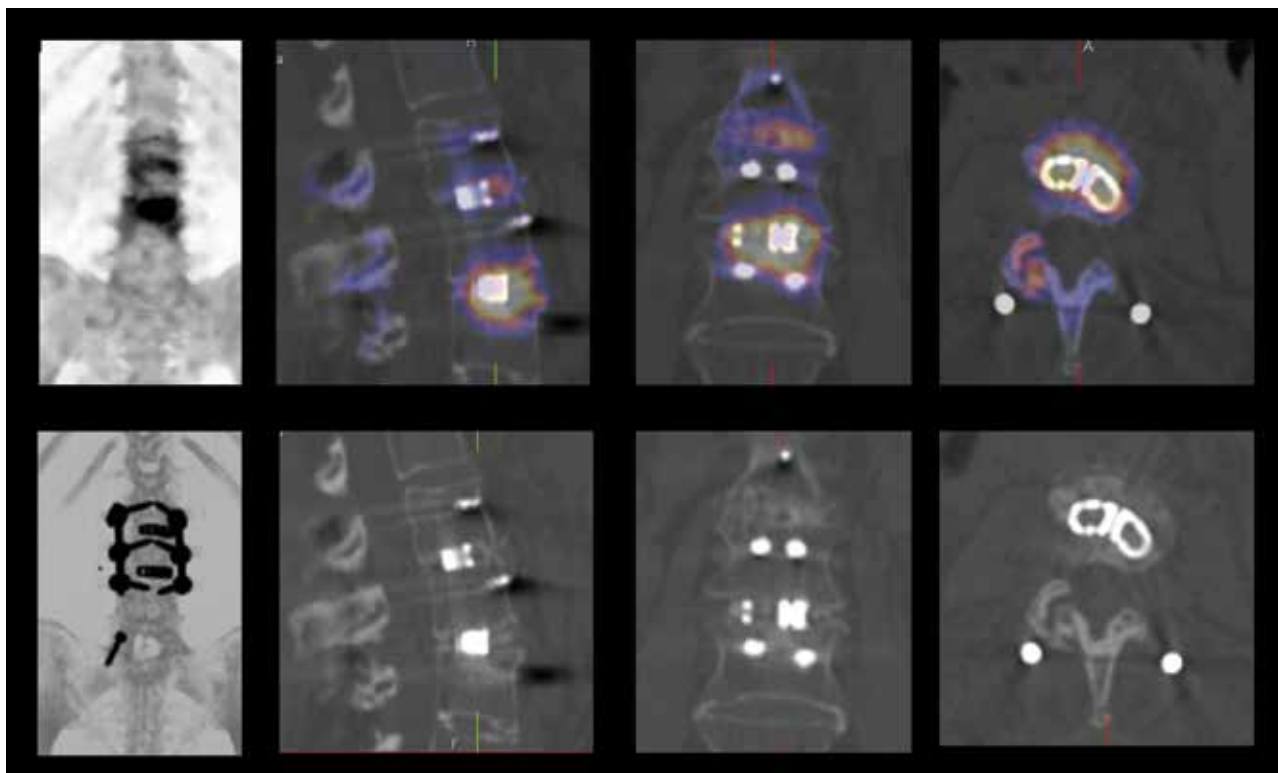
Fusion of xSPECT Bone and CT shows increased tracer uptake in the upper end plate and adjacent body of the L4 vertebrae and the L3-L4 intervertebral disc space. There is also mild uptake in the L2-L3 intervertebral disc space. CT images at the level of the upper end plate of the L4 vertebrae show irregularity in the surface of the upper end plate, which reflects impression fracture along with subchondral sclerosis. The right upper intra-articular facet of the L4 vertebrae shows increased uptake probably reflecting increased shear stress due to instability of lumbar fusion.
